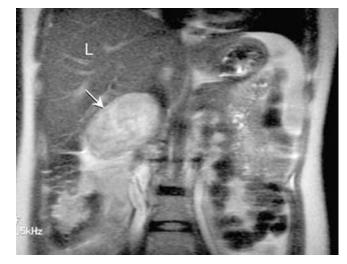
Coronal magnetic resonance image taken in a 32-week pregnant woman shows a right-sided pheochromocytoma (*arrow*) and its position relative to the liver (L) above it.
